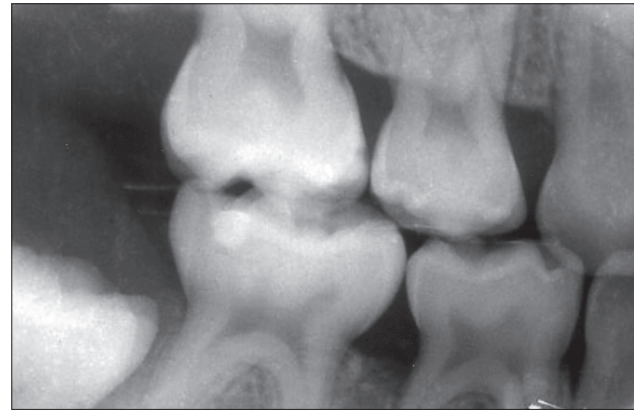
Initial bite-wing radiograph of case No. 5. Alveolar bone loss is apparent only affecting the distal surface of tooth S.
